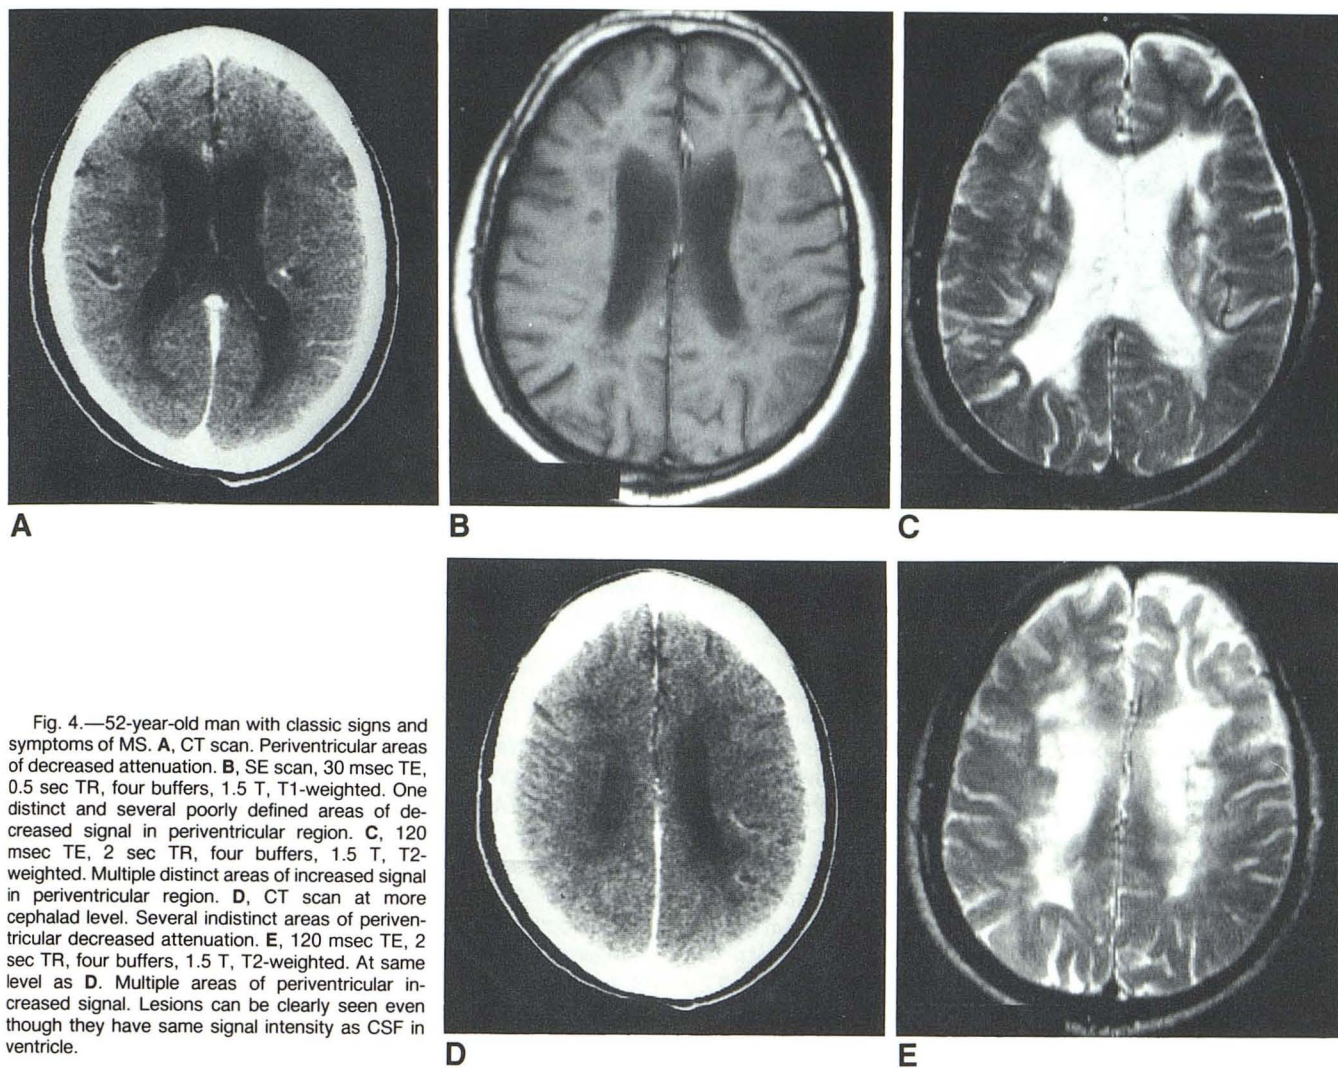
52-year-old man with classic signs and symptoms of MS. A, CT scan. Periventricular areas of decreased attenuation. B, SE scan, 30 msec TE, 0.5 sec TR, four buffers, 1.5 T, T1-weighted. One distinct and several poorly defined areas of decreased signal in periventricular region. C, 120 msec TE, 2 sec TR, four buffers, 1.5 T, T2-weighted. Multiple distinct areas of increased signal in periventricular region. D, CT scan at more cephalad level. Several indistinct areas of periventricular decreased attenuation. E, 120 msec TE, 2 sec TR, four buffers, 1.5 T, T2-weighted. At same level as D. Multiple areas of periventricular increased signal. Lesions can be clearly seen even though they have same signal intensity as CSF in ventricle.
